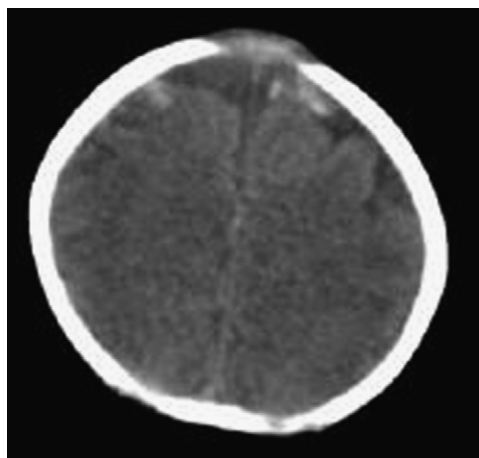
The computed tomography (CT) scan demonstrates a subdural hematoma in a 6-week-old infant. Subdural hematomas may not present as space-occupying lesions but may cause significant morbidity when evacuated because of significant brain swelling. (Used with permission of the American Academy of Pediatrics: Visual Diagnosis of Child Abuse CD-ROM, ed. 3, American Academy of Pediatrics, 2008.)
